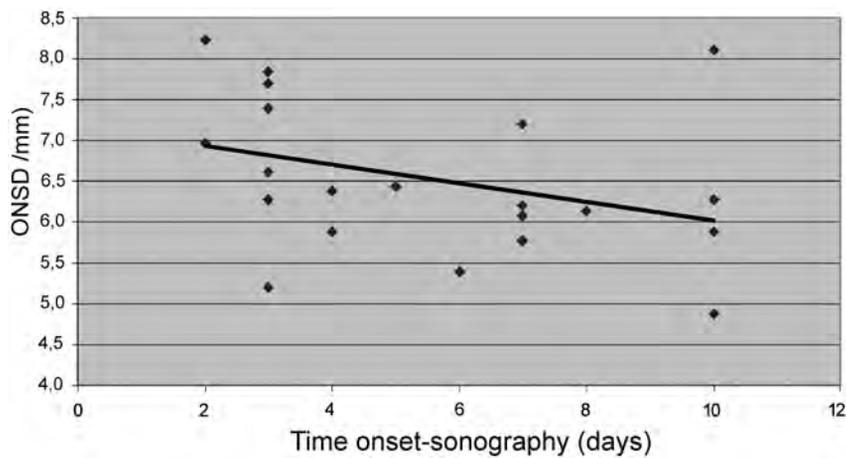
Optic nerve sheath diameter and delay from symptom onset. Correlation between the delay of the transorbital sonography examination (days from symptom onset) and optic nerve sheath diameter in the affected eye ($r = -0.42$, $P = .06$).
